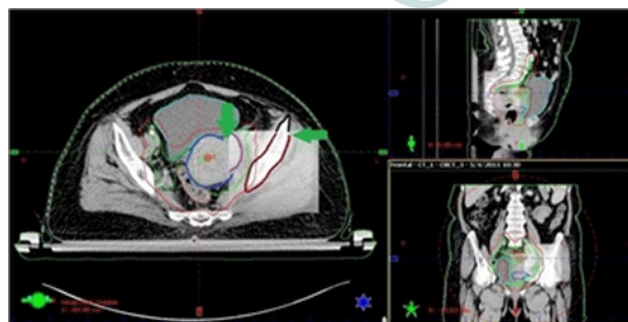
The perfect bone to bone matching of a patient with the reference computed tomographic image and the uterine shift between the two scans to negate the effect of the patient's setup errors
